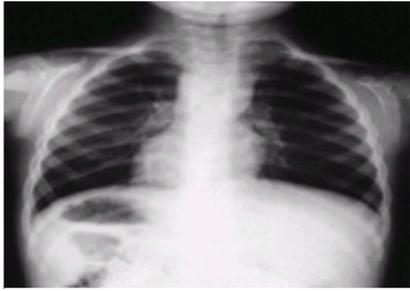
The radiographic changes of hyperparathyroidism are seen in this patient with renal osteodystrophy. Notice the resorption at the distal ends of the clavicles.
